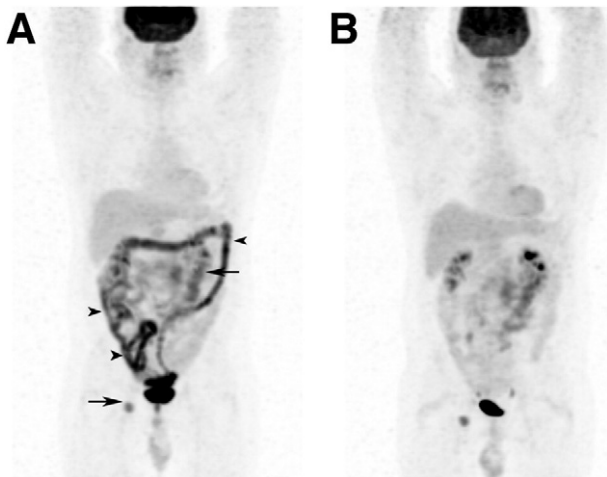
(A) Maximum intensity projection image of a 43-year-old man with newly diagnosed follicular grade 1 lymphoma, with abdominal and right inguinal lymphadenopathy (stage II), who underwent FDG PET scan for staging. He was known to have type 2 diabetes on metformin therapy. The scan demonstrated abnormal focal, moderately increased FDG uptake at the known sites of lymphoma (arrows) as well as moderate to intense diffuse FDG uptake throughout the bowel (arrowheads), most markedly in the large intestines. There was also physiological urinary tracer pooling in the bladder and physiological FDG accumulation in the brain, myocardium, and liver. (B) A repeat PET scan was performed 4 days later after 72 hours of withholding metformin, with resolution of reactive bowel uptake and better visualization of known sites of lymphoma. Physiological tracer uptake in the collecting system of the kidneys and intense urinary tracer pooling in the bladder were also noted.
